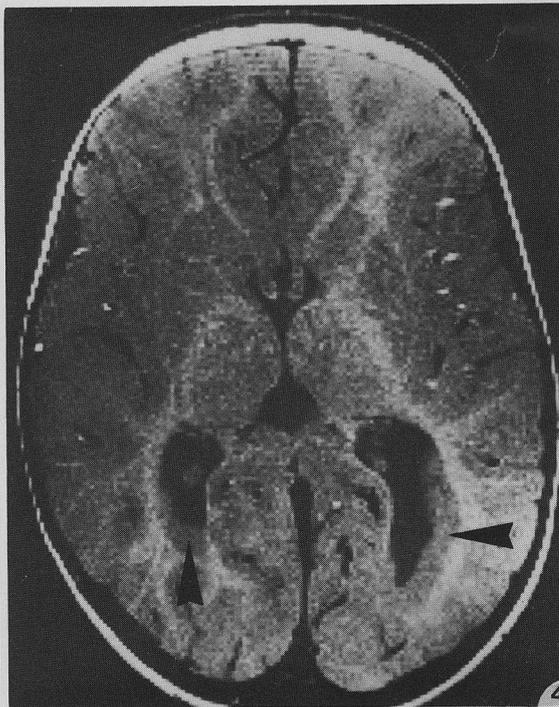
Heterotopia of gray matter around both occipital horns, hypoplasia of corpus callosum. MRI-T1-weighted axial section, case 7.
